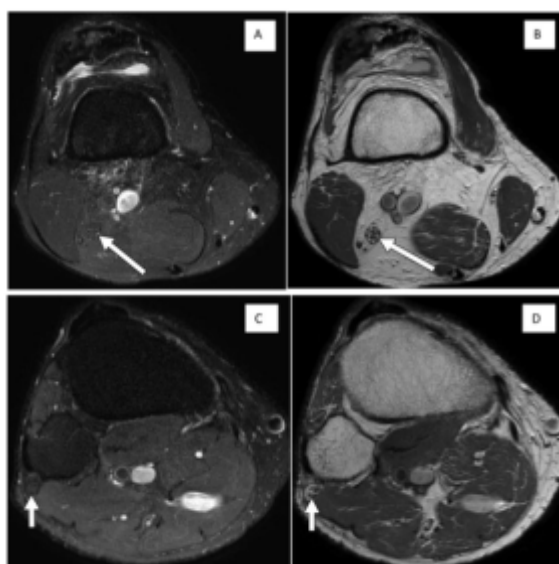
The image caption describes findings in a 66-year-old man with a history of uncontrolled diabetes mellitus who presented with knee pain but no neuropathic symptoms. Sequential axial MRI images including fat-suppressed proton density (labeled A and C) and non fat-suppressed proton density (labeled B and D) show enlarged tibial nerves (indicated by arrows in A and B) and common peroneal nerves (arrows in C and D). These nerves exhibit atrophic-appearing fascicles and prominent intraneurial fat, suggestive of chronic diabetic neuropathic changes despite the absence of overt symptoms.
